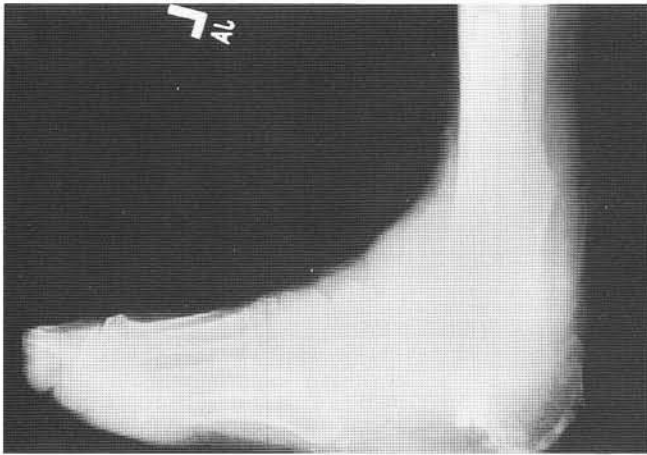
Postoperative lateral radiograph showing the intramedullary rod in place.
